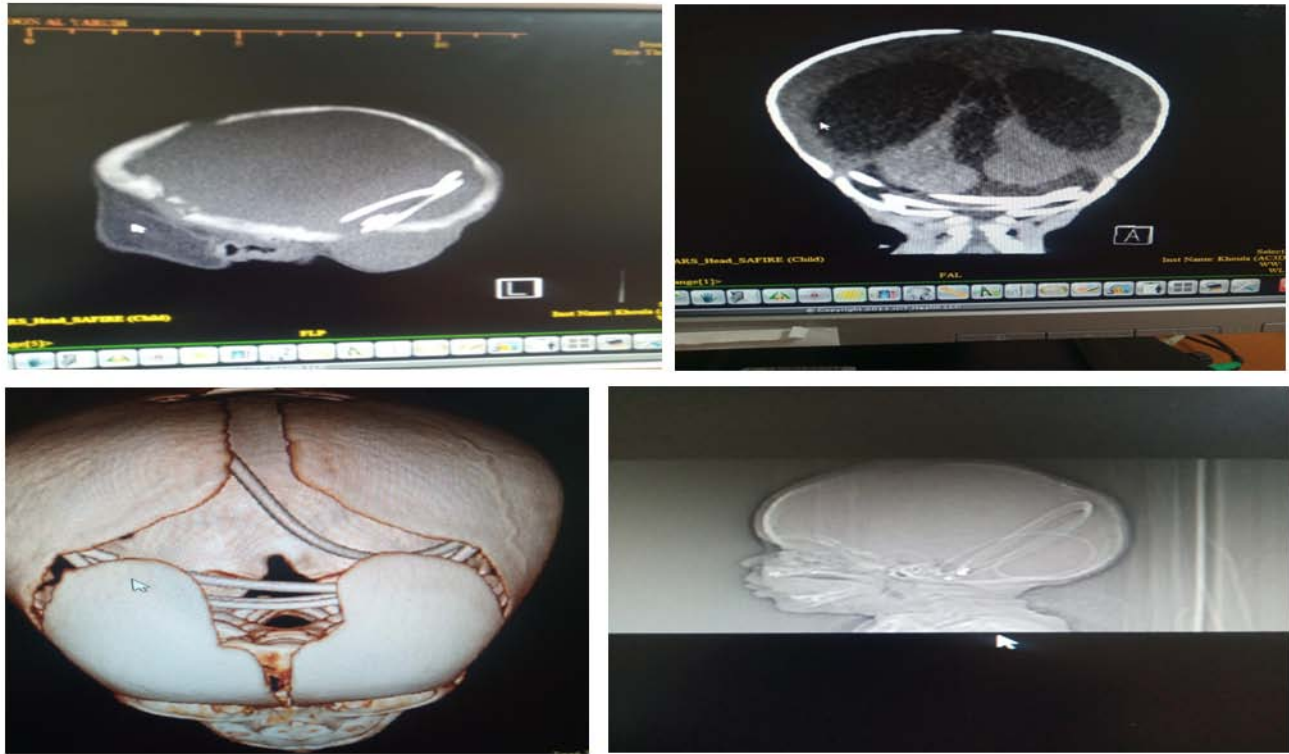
CT showing cranial migration of shunt
